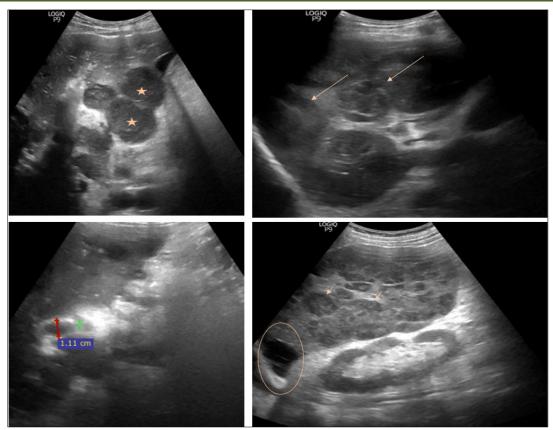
Abdominal ultrasound using a deep probe showing hepatosplenomegaly with macronodules in the liver (long arrow) and spleen (short arrow), with an effusion (circle), dilatation of the main bile duct and adenopathies in the hepatic hilum (star)
